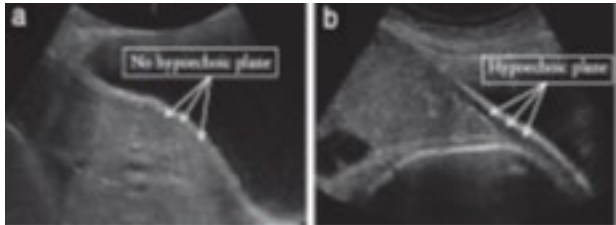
Ultrasound features of abnormally invasive placenta⁴
